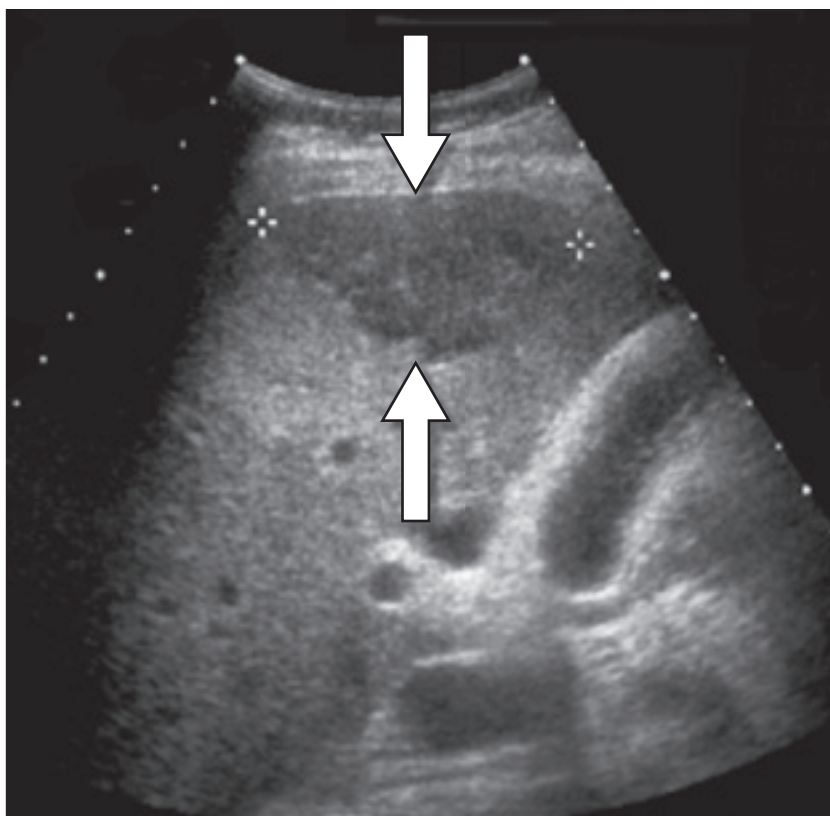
Ultrasound image of the liver showing solitary, largely hypoechoic mass (arrows).
